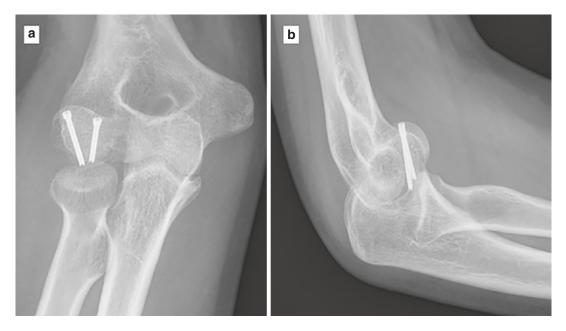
(a) AP and (b) Lateral radiograph taken the day following final clinic appointment demonstrating pull out of the headless compression screws and vertical translation of the capitellum
